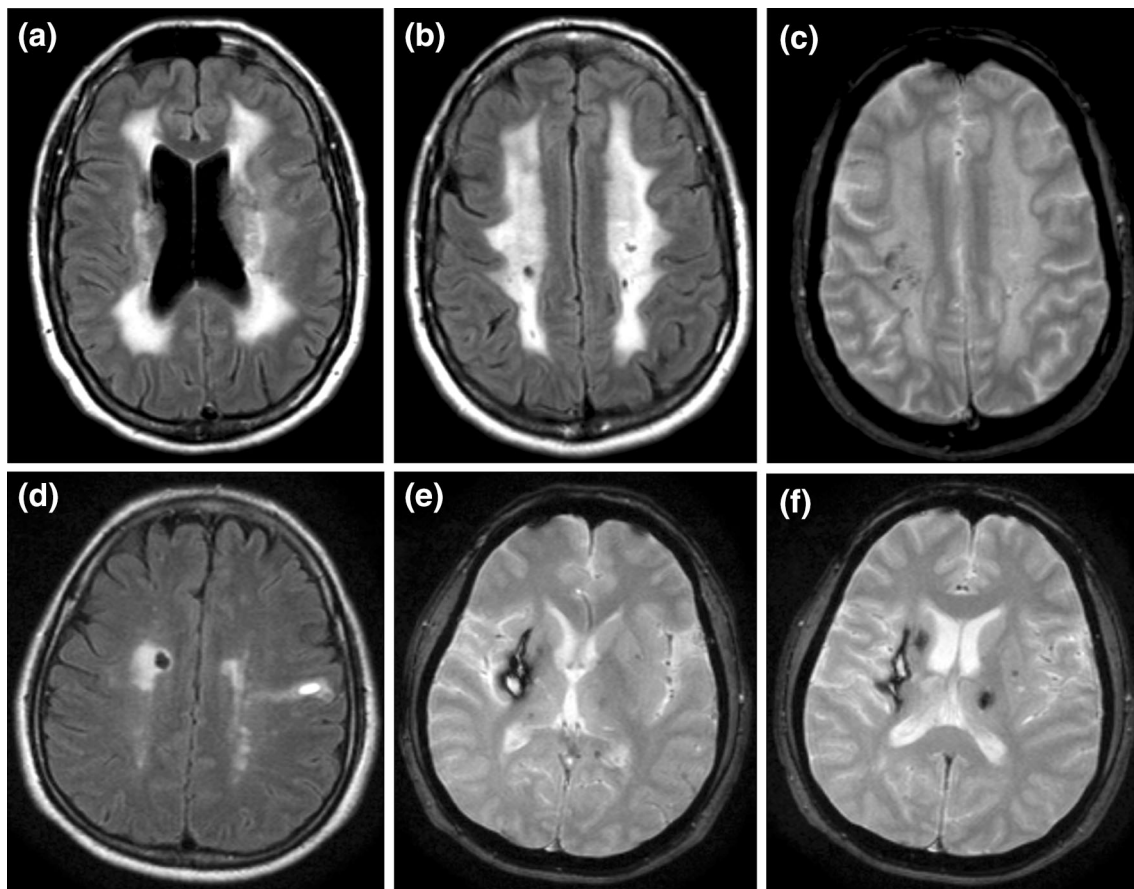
MRI appearances in 2 patients with COL4A1 mutations. T2/FLAIR sequences showing confluent white matter hyperintensities (a, b, d). T2*GRE sequences show cortical-subcortical microbleeds (c, f) and a previous haemorrhage (e, f)
